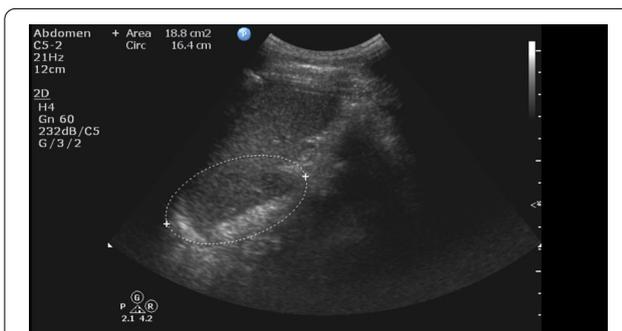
Left upper quadrant view during a FAST (Focused Assessment with Sonography for Trauma) examination. A mildly hypoechoic crescent-shaped region is showcased (indicated by the outlined dashed oval area) medially to the upper half of the spleen (S), raising suspicion of a possible perisplenic hematoma
